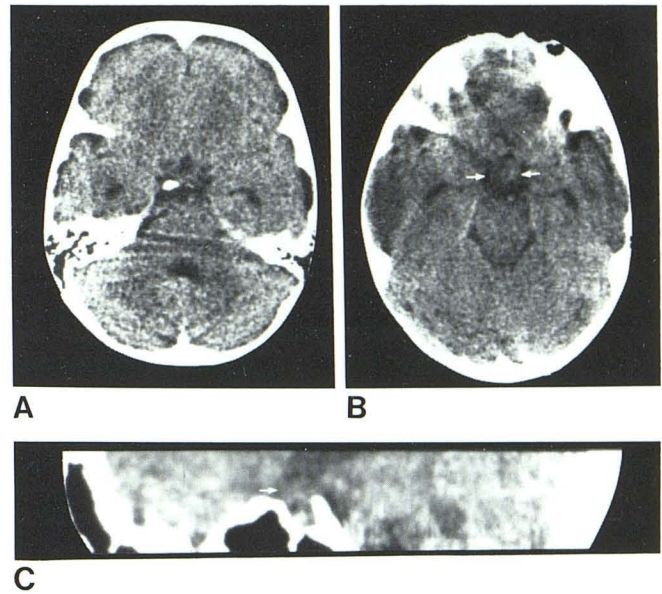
25-year-old woman with progressive bitemporal hemianopia due to optochiasmatic arachnoiditis (ICS type 3). A, Axial CT with 1.5 mm section shows partial obliteration of suprasellar cistern. B, Optic chiasm appears prominent with indistinct margin (*arrows*). C, Sagittal reformatted image shows partial effacement of recesses of third ventricle with matted chiasm and optic nerve complex (*arrow*). Sella is partly empty.
